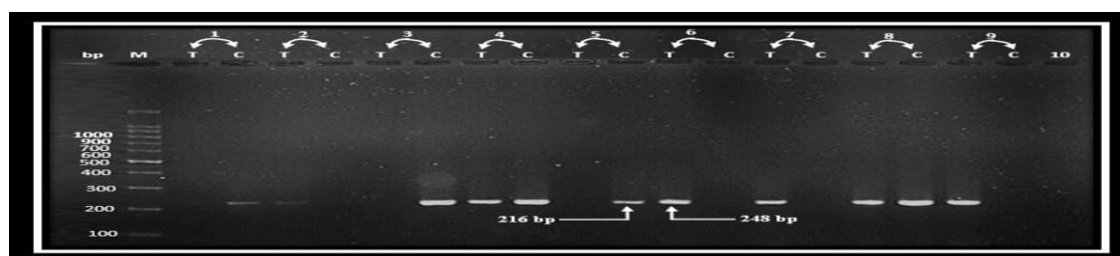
Electrophoresis of ARMS PCR products of IL-4 gene -590 (C>T) on 1.5 % agarose at 70 volt for one and half hour. Presence of one band in C lane and absence of this band in T lane refer to the genotype CC. In contrast, presence of one band in T lane and absence of this band in C lane refer to the genotype TT. Presence of two bands in both lanes refers to the genotype CT.)
